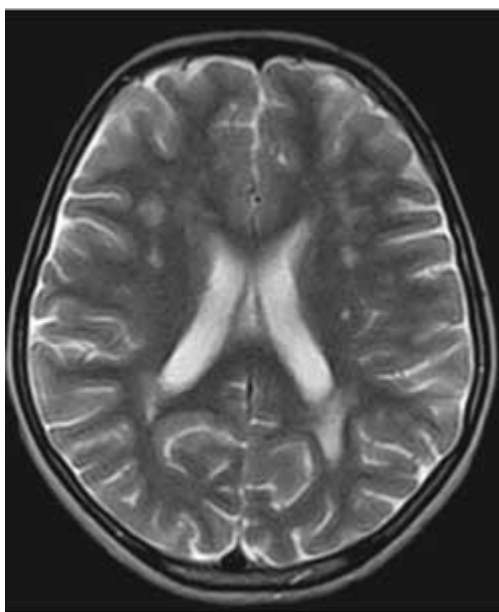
MRI Image, T2 axial section shows white matter hyperintensities.
